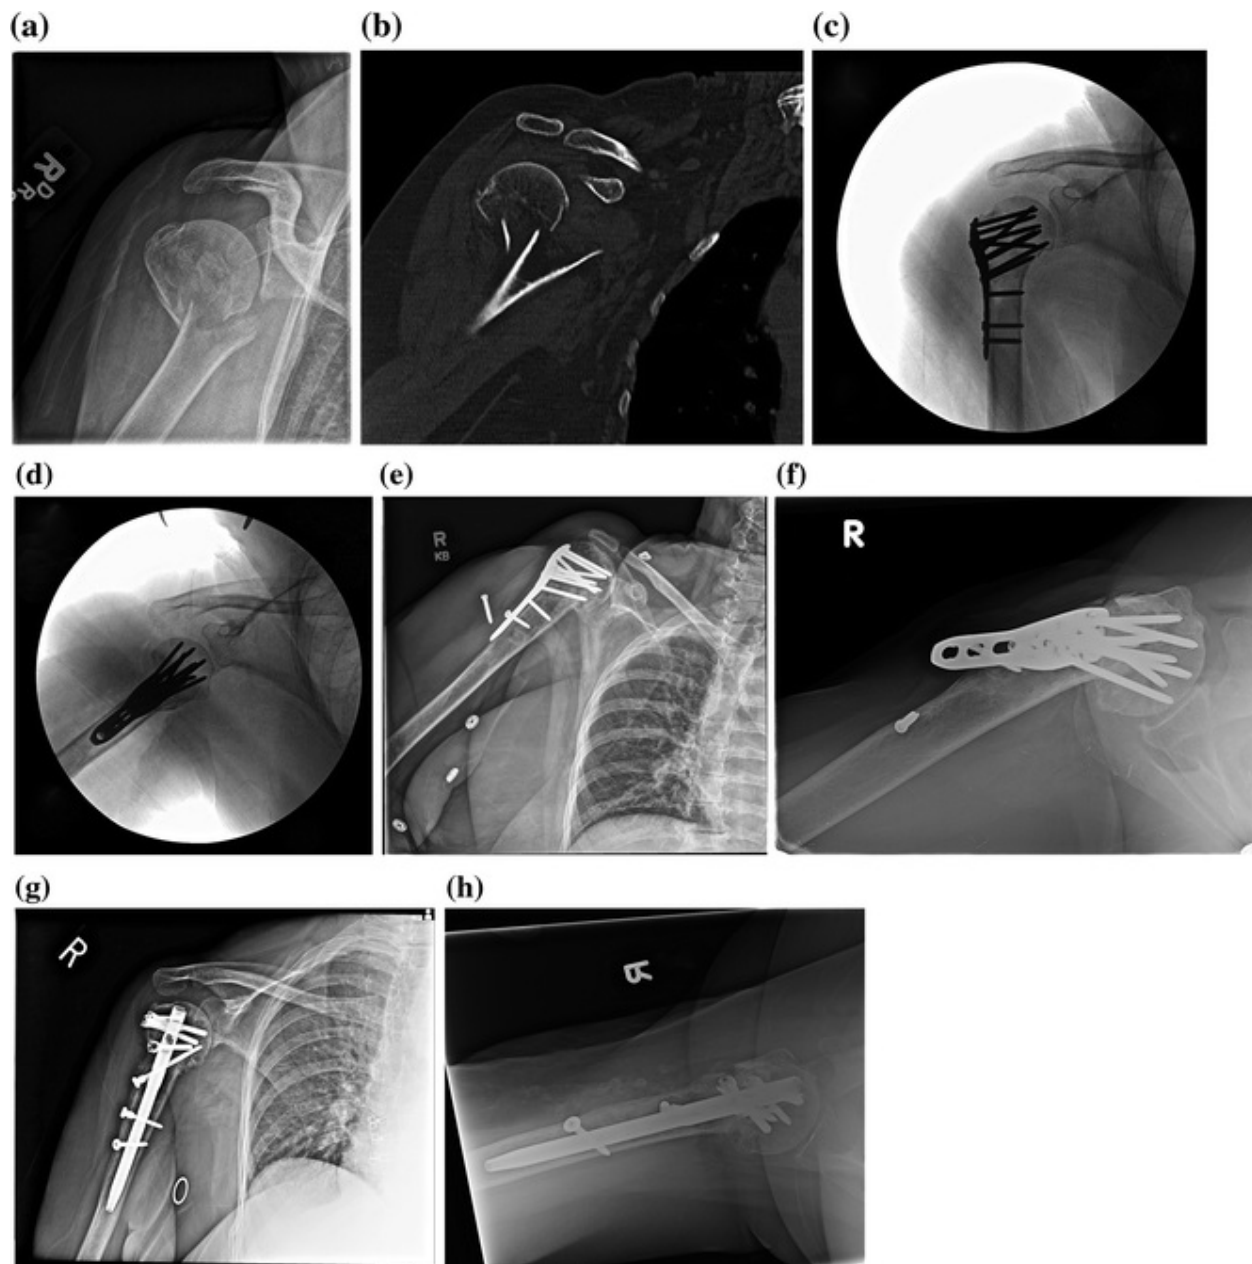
A 60-year-old female sustained a surgical neck fracture after a ground-level fall, seen on anteroposterior (AP) (a) and coronal computed tomography (b). Underwent open reduction and internal fixation with locked plating and allograft on AP (c) and lateral (d) views. Presented two years postoperatively with continued pain and immobility with varus collapse and hardware pullout on AP (e) and axillary (f) views. Patient underwent hardware removal and revision fixation, using an interlocked intramedullary nail, allograft, and bone morphogenic protein, with union at three months on AP (g) and axillary (h) views
